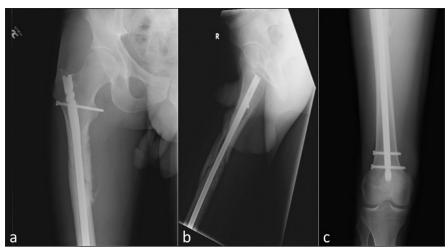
Anteroposterior radiograph of the proximal femur (a) and lateral (b) and anteroposterior (c) radiographs of the distal femur showing femur fracture without evidence of healing in a 30-year-old man with continued pain with weight bearing 7 months after his leg was crushed by a forklift.
